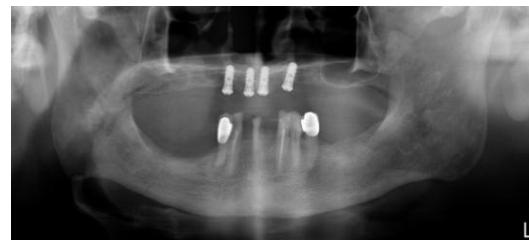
Post-op panoramic radiograph
